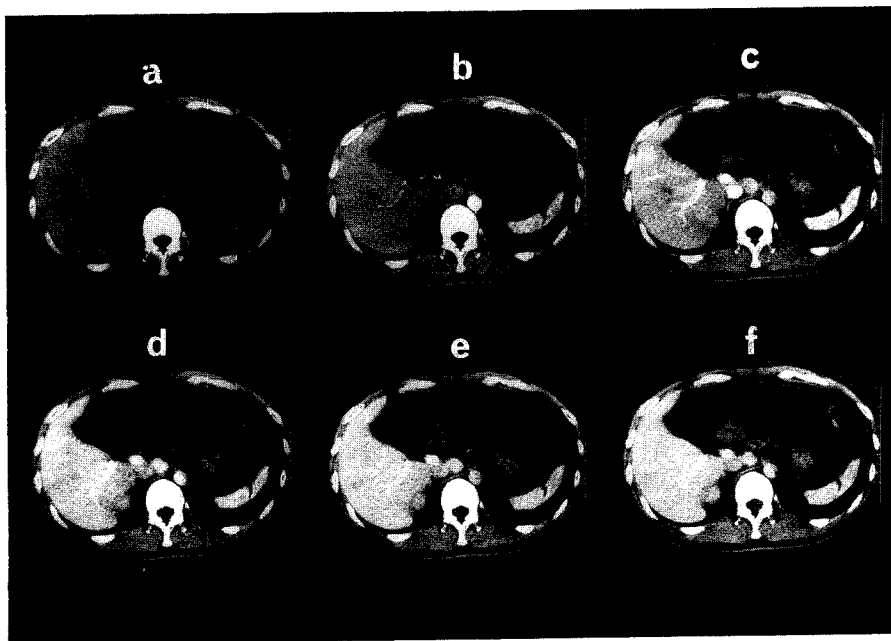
Dynamic CT images of the main trunk of the portal vein and the abdominal aorta. Starting at 4 sec after a bolus injection of non-ionic hypo-osmotic contrast medium, 11 images of 1 sec scanning at 2 sec intervals and 4 images of 1 sec scanning at 5 sec intervals were obtained; i.e., 15 images were taken during 57 sec period. a ~ f, the images taken at different times after the start of the scanning; a, at 3 sec; b, at 9 sec; c, at 21 sec; d, 27 sec; e, 33 sec; and f, 39 sec.
